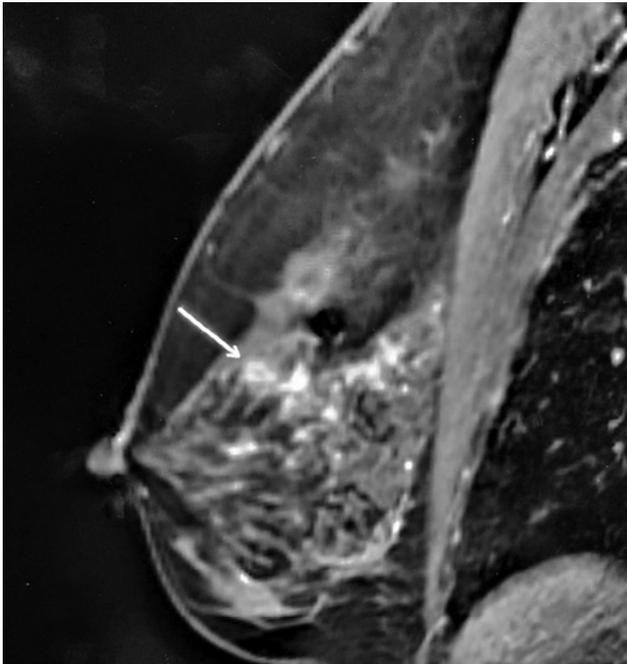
2009 right breast MRI upper outer quadrant.
